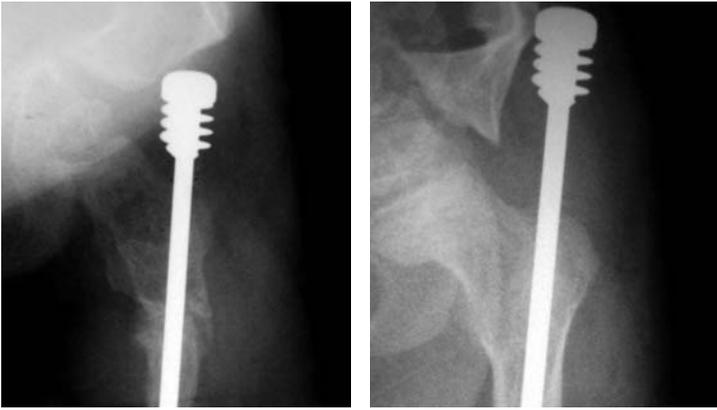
Left. Postoperative radiograph demonstrating the Fassier-Duval nail anchored in the greater trochanteric apophysis. Right. Postoperative radiograph two-years later demonstrating proximal migration of the Fassier-Duval nail following screw pull-out.
